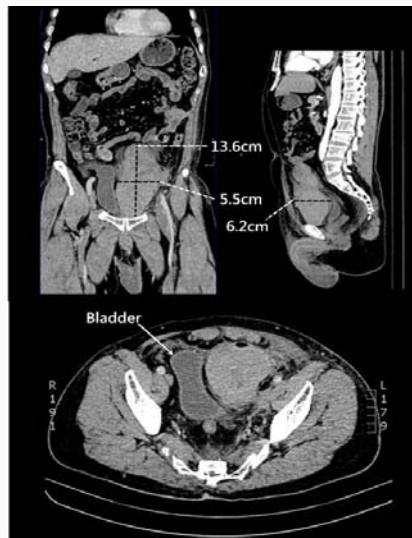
These images show a massive hematoma originates from Retzius space with effect on bladder and bowel loops (Coronal plane, sagittal plane and horizontal plane by CT multiplanar reformation).
